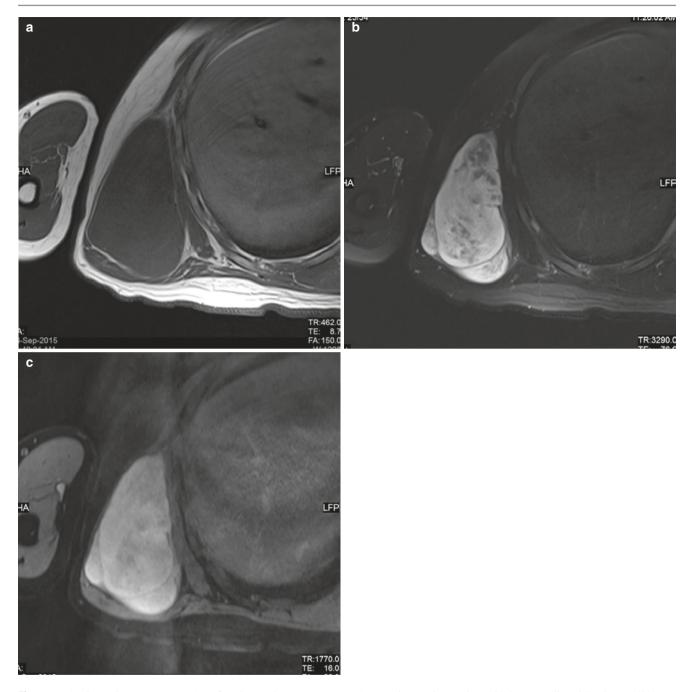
Ancient schwannoma. (a) T1W, (b) T2W, and (c) postcontrast T1W MR images in a patient with long-standing right chest wall lump
